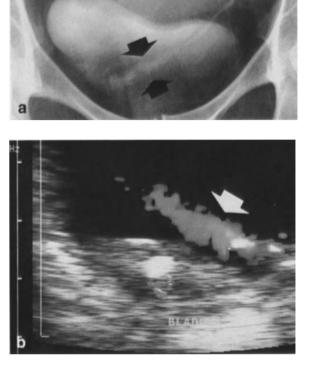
Ureteral jets. a Single jet (*arrows*) splashing against the opposite bladder wall. b Doppler ultrasound appearance of ureteral jet (*arrow*)
